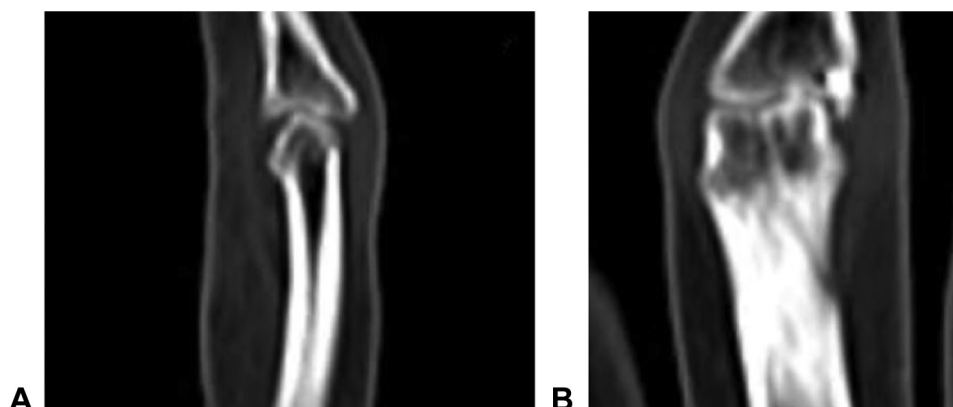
Selected computed tomography images of the PIP joint to evaluate posttraumatic changes prior to “hemi-hemi” reconstructive surgery. A Sagittal and B frontal views.
